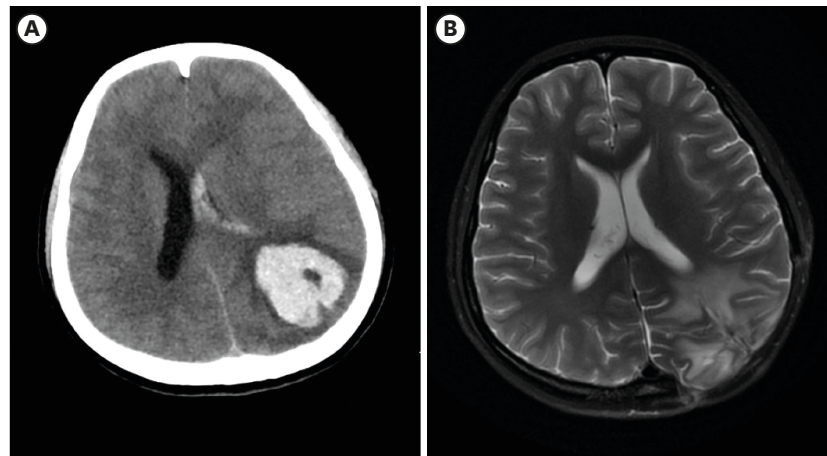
Gestational trophoblastic neoplasia with cerebral metastasis. (A) Before craniotomy, computed tomography showed left parietal-occipital metastatic tumor with cerebral hemorrhage ruptured into left lateral ventricle, peritumoral edema, left lateral ventricle compression, and midline shift. (B) One month after craniotomy, T2-weighted magnetic resonance image showed encephalomalacia at left parietal-occipital lobe. Bilateral ventricles were symmetric without midline shift.
